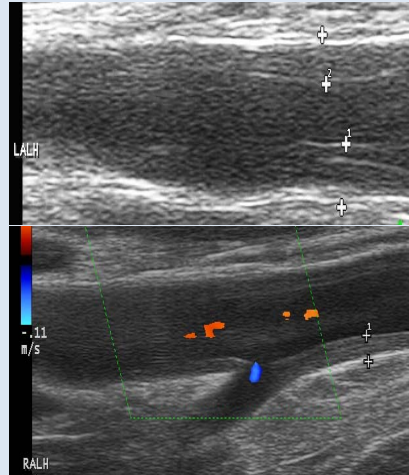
Ultrasound of the left (top) and right (bottom) axillary arteries with increased IMT and stenosis
